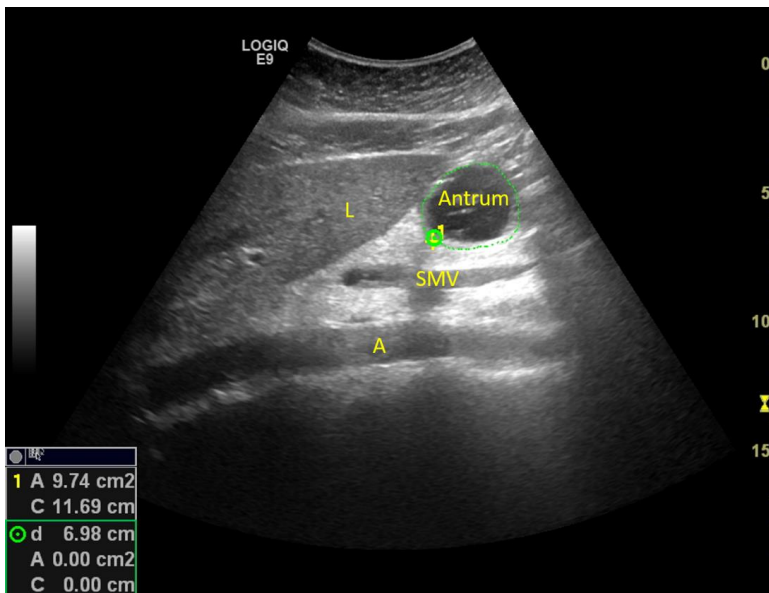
Ultrasound image of the antrum after ingesting a liquid meal. In this section, we find the antrum in close relation to the left liver lobe (L) and the aorta (A) and superior mesenteric vein (SMV) which are visible posterior to the antrum serving as internal landmarks.
